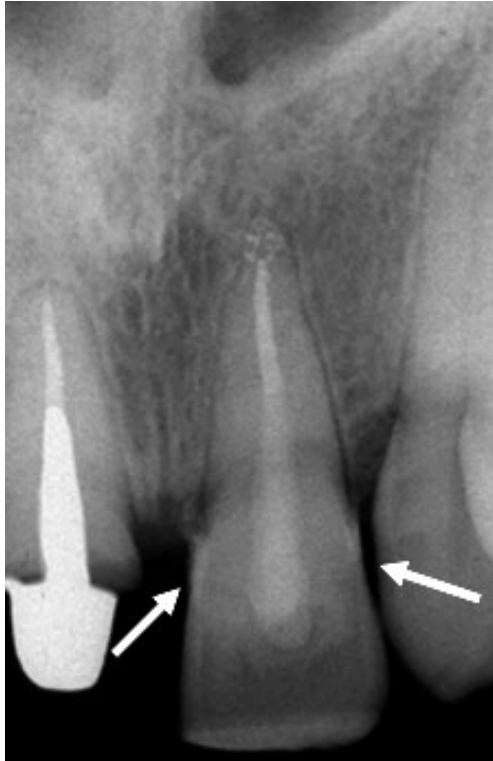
Radiographic examination immediately after reattachment shows a good adaptation of the fragment.
